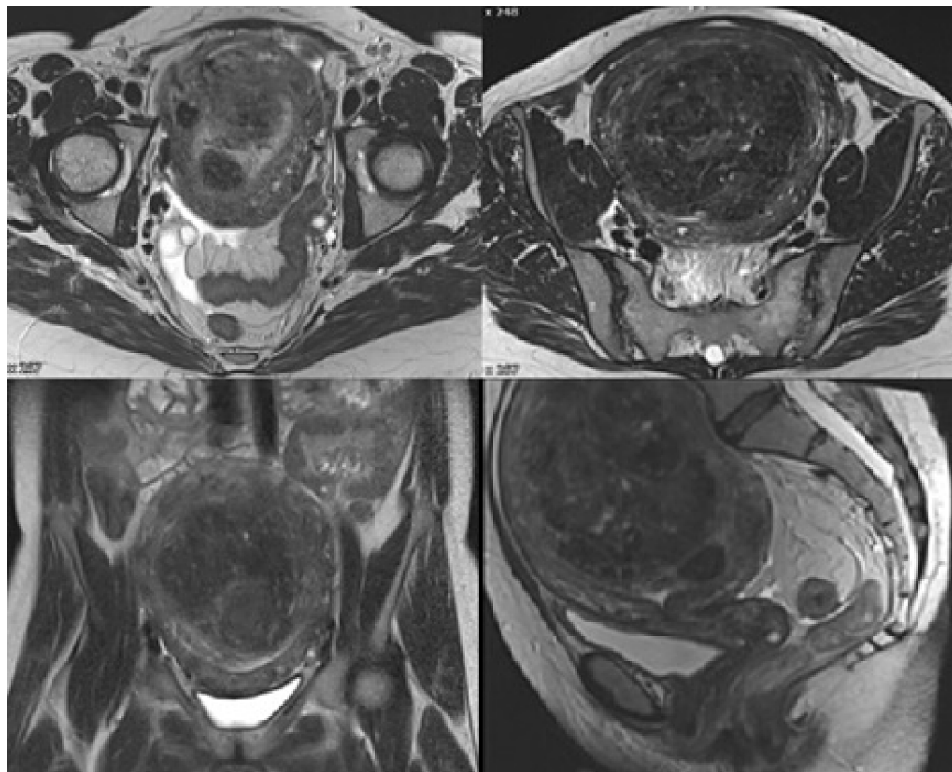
MRI with large myomatous uterus
